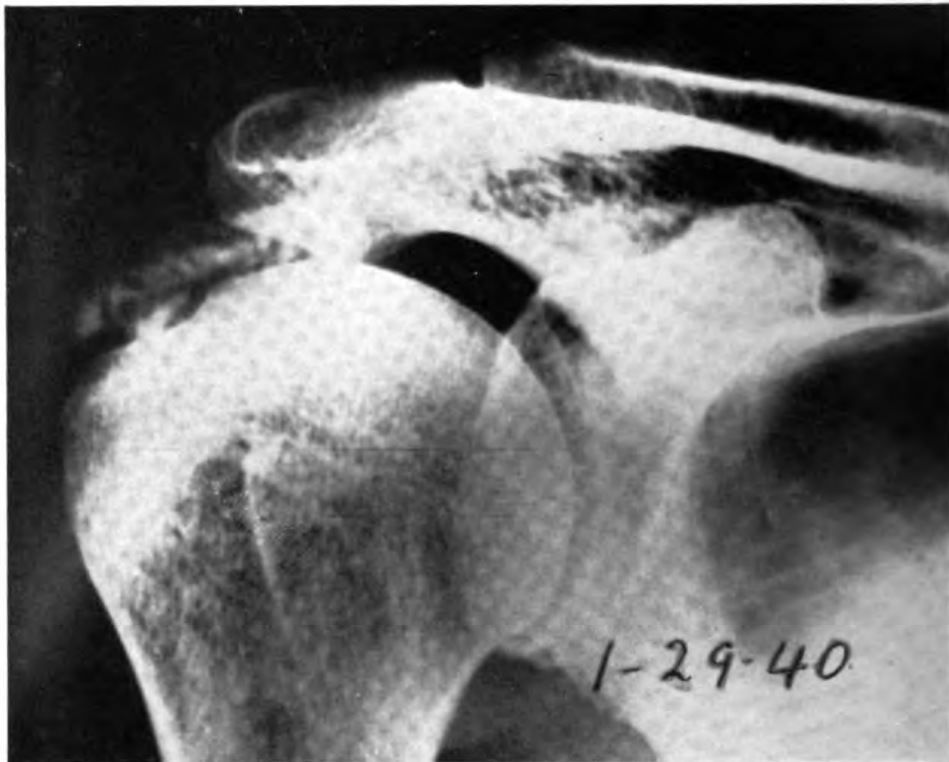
CASE 22.—PRIOR TO ROENTGEN THERAPY
